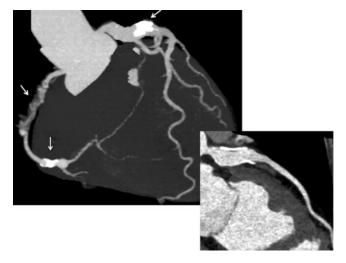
CT coronary angiograms (Patient 1). The angiogram revealed segmental stenosis of the right coronary artery. Coronary artery calcification at segments 2, 4, and 5 was detected. A giant calcified coronary aneurysm at the bifurcation of the left coronary artery was found.
